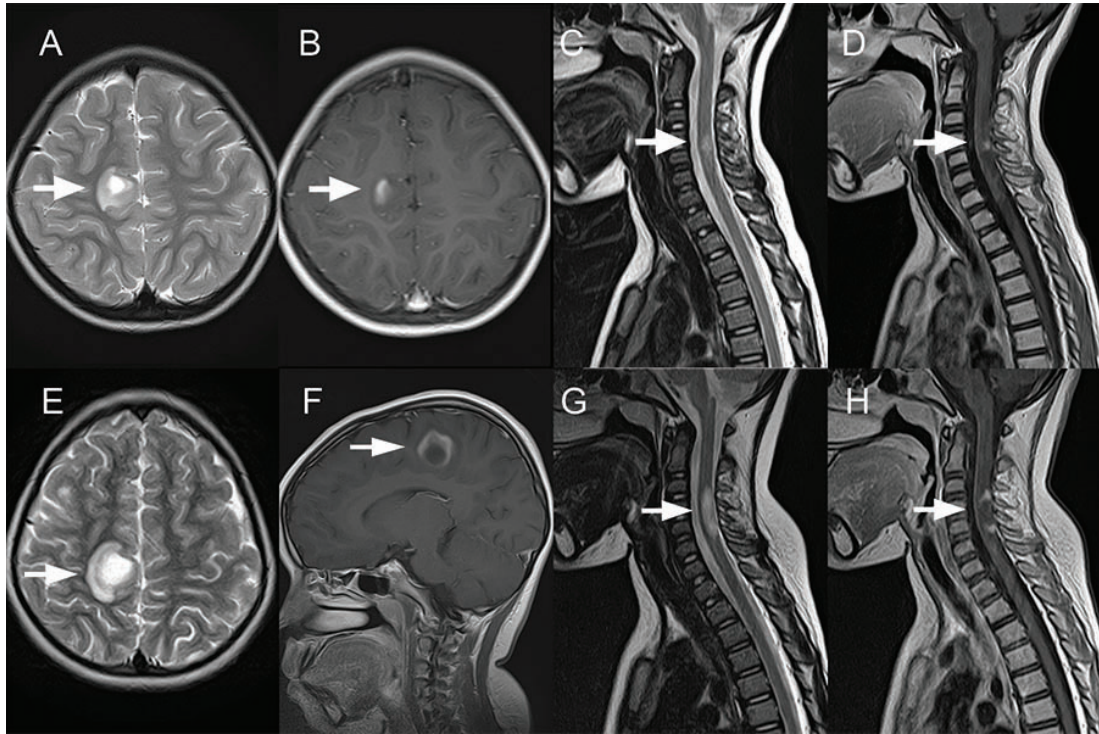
MRI images in Patient 1 during her first presentation with bilateral visual loss, left thigh weakness and impaired proprioception in both distal lower limbs. Axial T2-weighted FSE (A) and axial T1-weighted FSE with gadolinium (B) brain images showing a focal area of acute demyelination (white arrow) in the right pre-central gyrus, medial convexity, i.e. corresponding to the motor cortex for control of the left lower limb. Sagittal T2-weighted FSE (C) and Sagittal T1-weighted FSE with gadolinium (D) of the cervical spinal cord showing a focal area of acute demyelination (white arrow) in the posterior cord (posterior column) at C4-5 region.
